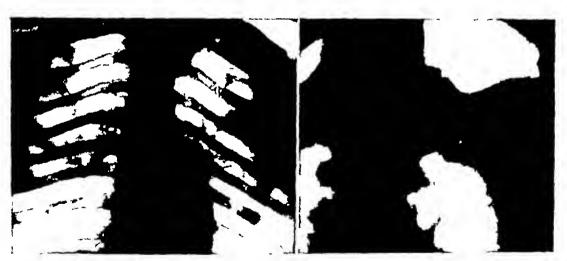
Boutine radiography does not reveal infiltrat at at the right pex.
